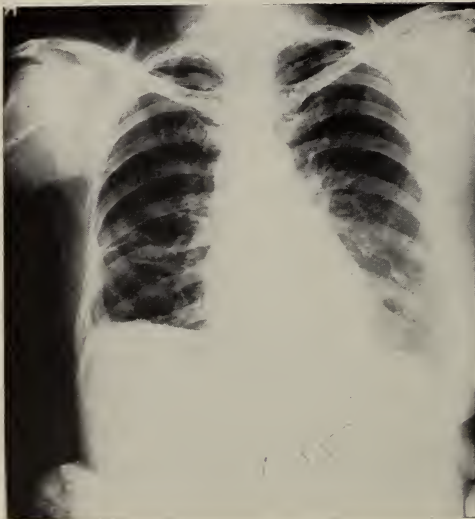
X-ray film of chest (Case 1) nine months after bilateral oophorectomy and adrenalectomy. Note resolution of right pleural effusion. Only thickening of the basal pleura on the right remains.
